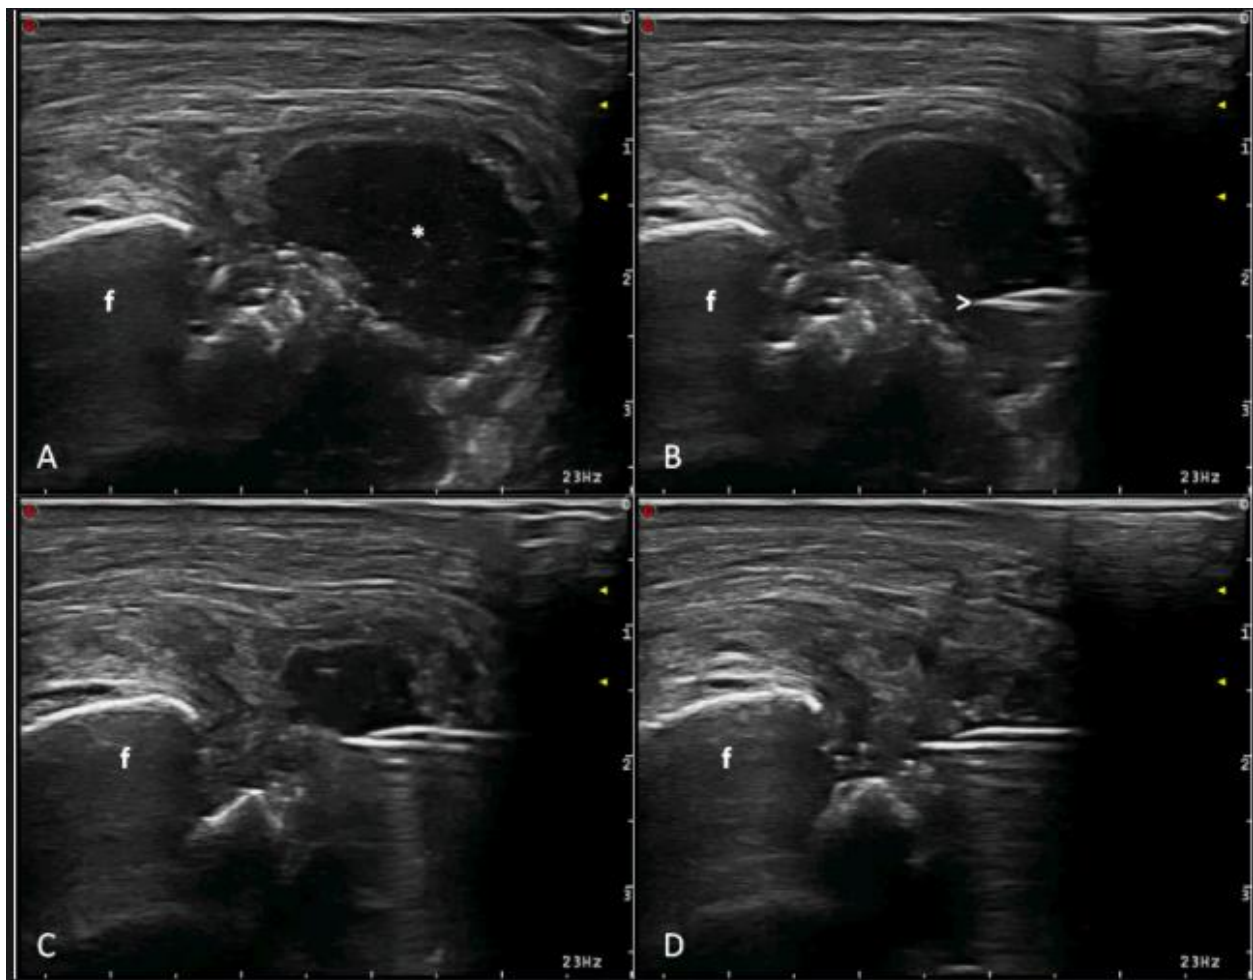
Ultrasound images showing the periosteal abscess (A) and different steps of its ultrasound guided aspiration (B-D). A. Transverse medial scan of the internal distal aspect of the femur showing a hypoechoic round fluid collection (asterisk). B. Tip of the needle placement within the abscess (arrowhead). C. Ultrasound guidance allows for the visualization of the tip of the needle that during the aspiration is maintained in the right position. D. Complete aspiration of the abscess. f=femur.
